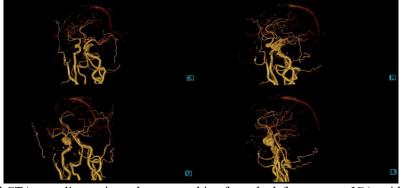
Admission cerebral CTA revealing an irregular outpouching from the left cavernous ICA, with a maximum cross-section of approximately 1.7×1.2 cm.
